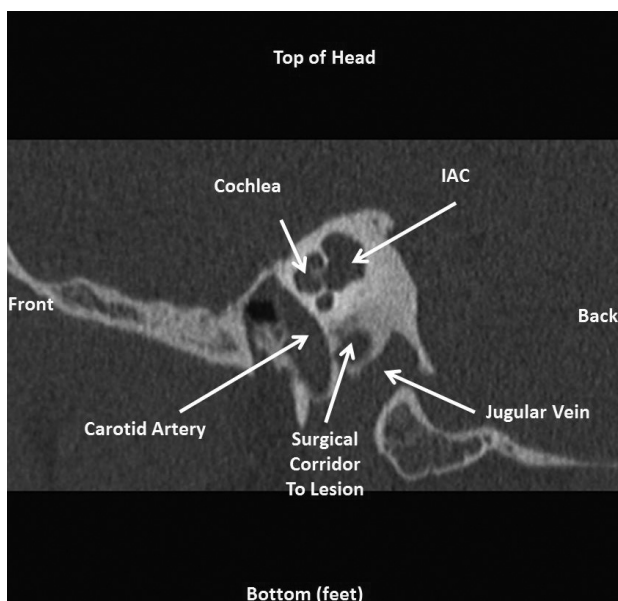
Sagittal CT image (looking from left to right in sequential slices) showing the anatomy of the surgical corridor in an infracochlear approach.
